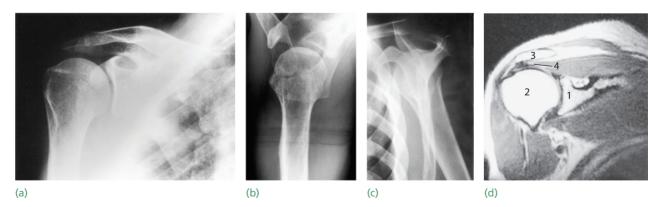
Imaging (a) Anteroposterior X-ray. (b) Axillary view showing the humeral head opposite the shallow glenoid fossa, and the coracoid process anteriorly. The acromion process shadow overlaps that of the humeral head. (c) Lateral view; the head of the humerus should lie where the coracoid process, the spine of the scapula and the blade of the scapula meet. (d) MRI. Key: 1 glenoid; 2 head of the humerus; 3 acromion process; 4 supraspinatus (with degeneration of the tendon).
